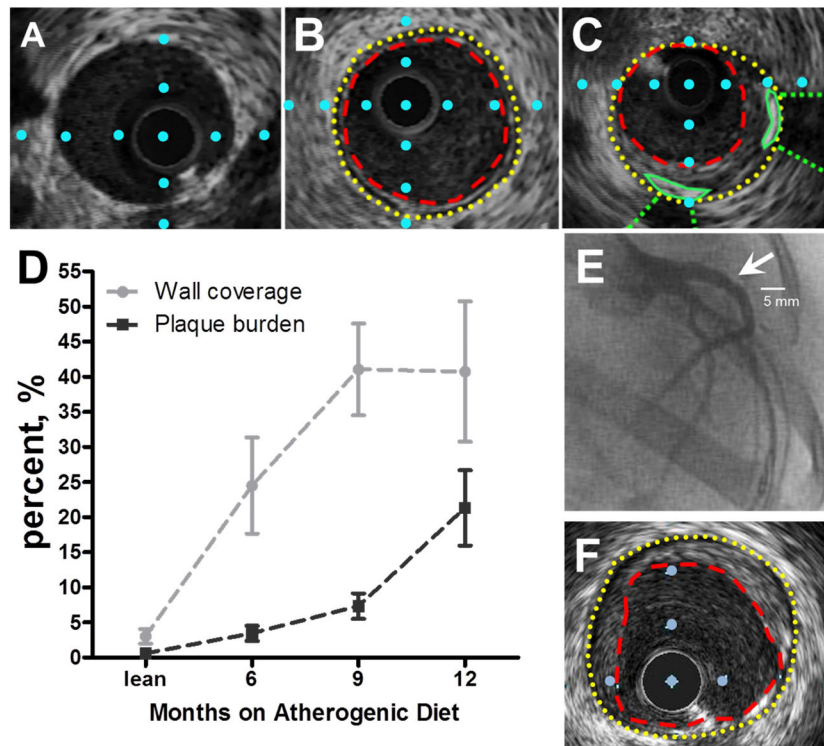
Intravascular ultrasound imaging of coronary arteries with varying stages of coronary artery disease in the repeat cross-sectional study
